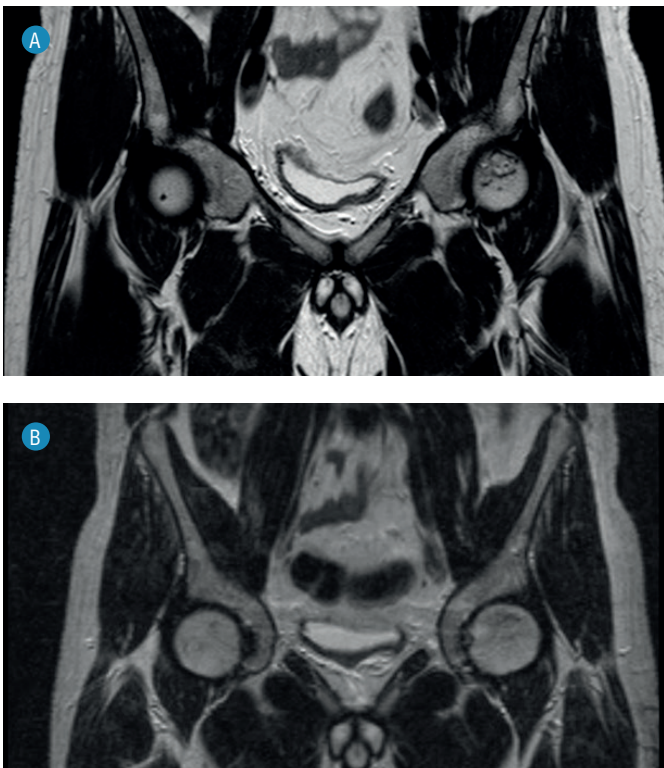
MRI of the hips of patient L., 35 years old with aseptic osteonecrosis of the left femoral head at 6 months (A) and 12 months (B) after treatment using regenerative interventional technologies (details in the text).
